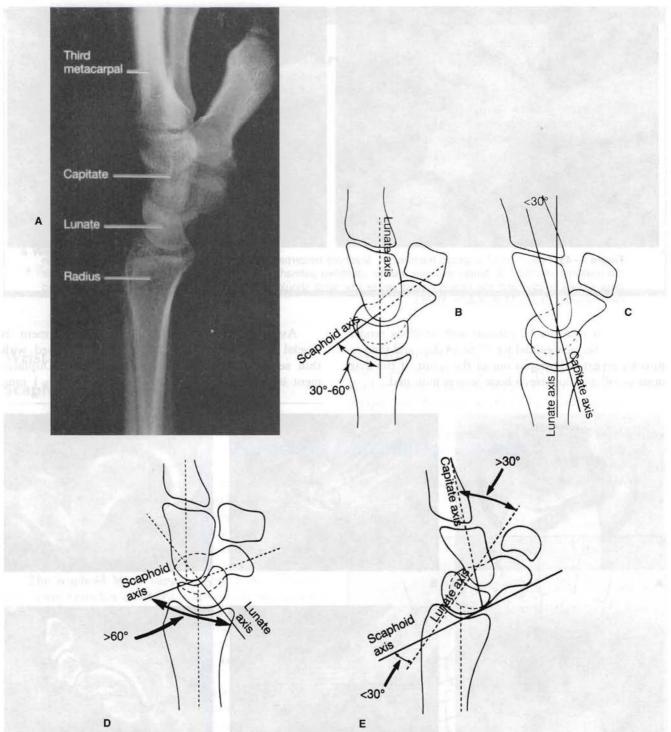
A*, Lateral radiograph shows the normal colinear relationship of the radius, lunate, capitate, and third metacarpal. With normal carpal alignment, the scapholunate angle is between 30 and 60 degrees (*B*) and the capitolunate angle is less than 30 degrees (*C*). Note that the scaphoid axis can be drawn through the center of the scaphoid, but it is also adequate and may be easier to draw a line along the inferior pole as shown in *C. D,* Dorsiflexion instability—dorsal intercalary segment instability (DISI)—is suspected when dorsal tilting of the lunate and volar tilting of the scaphoid are present with a resulting increase in the scapholunate angle to more than 60 degrees. *E,* Palmar flexion instability—volar intercalary segment instability (VISI)—is suspected with volar tilting of the lunate, resulting in a scapholunate angle of less than 30 degrees and/or a capitolunate angle of more than 30 degrees. *F,* DISI parameters for radioscaphoid, radiolunate, and scapholunate angles. (*A,* From Honing EW: Wrist injuries. Part 2: Spotting and treating troublemakers. Physician Sports Med 26[10]:62, 1996; *B*–*E,* from Mann FA, Gilula LA: Posttraumatic wrist pain and instability: a radiographic approach to diagnosis. In Lichtman DM, Alexander AH [eds]: The Wrist and Its Disorders, 2nd ed. Philadelphia, WB Saunders, 1997, p. 105; *F,* from Regional Review Course in Hand Surgery. Rosemont, Illinois, American Society for Surgery of the Hand, 1991, p. 12–21.)
